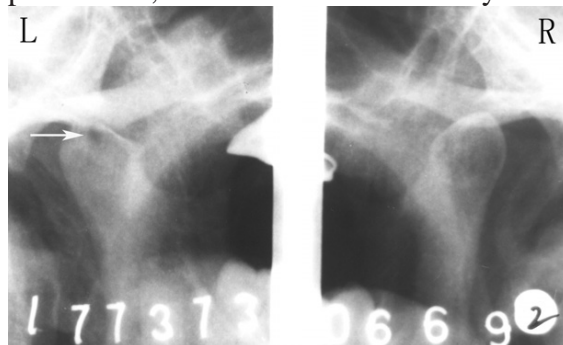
Transpharyngeal radiograph. A subcortical radiolucent lesion (*arrow*) was found to be located within the left condyle.
